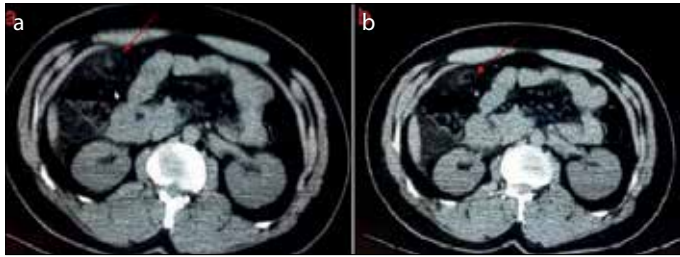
a, b. Computed tomography scan images of the patient
